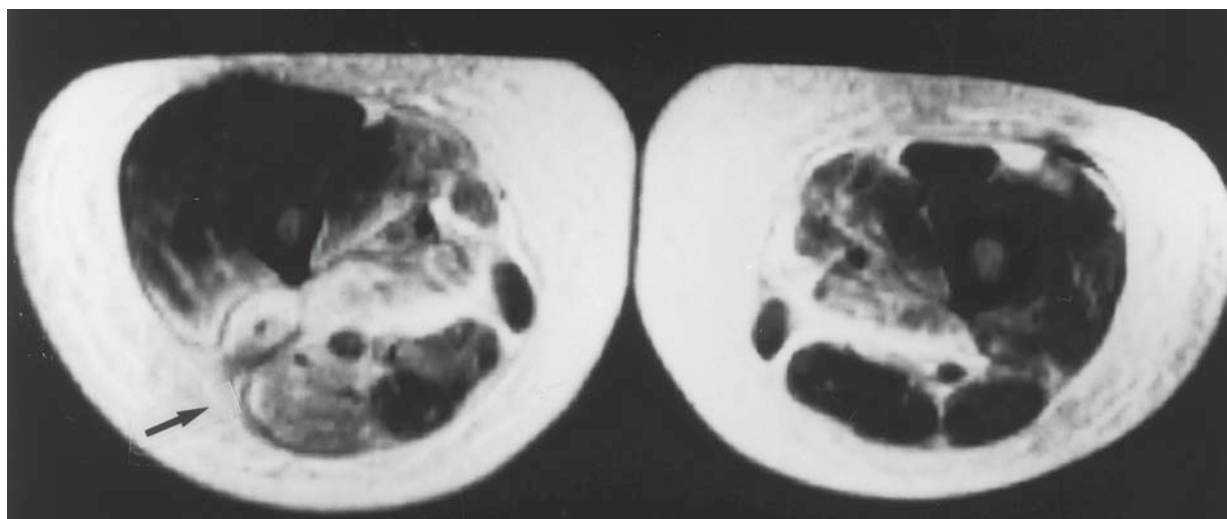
MRI showing T2 weighted images of the right thigh (left) and left thigh (right). Diffusely increased signal is seen involving the muscles of the posterior and medial compartments of the right thigh, biceps femoris, and semimembranosus (left, *see arrow*) compared with the left normal thigh (right).
